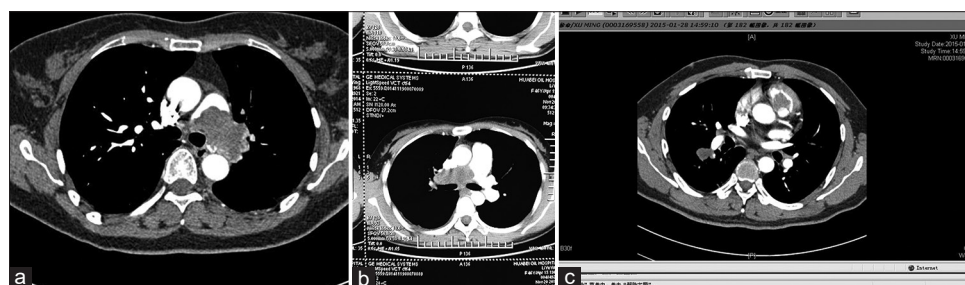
(a) Computed tomography scan showing a lobulated soft tissue mass filling the main and left pulmonary artery in one case with pulmonary artery sarcoma. (b) Filling defects in right pulmonary artery in another case with pulmonary artery sarcoma. (c) The lung and the outflow tract of right ventricle involvement in another case with Pulmonary artery sarcoma.
